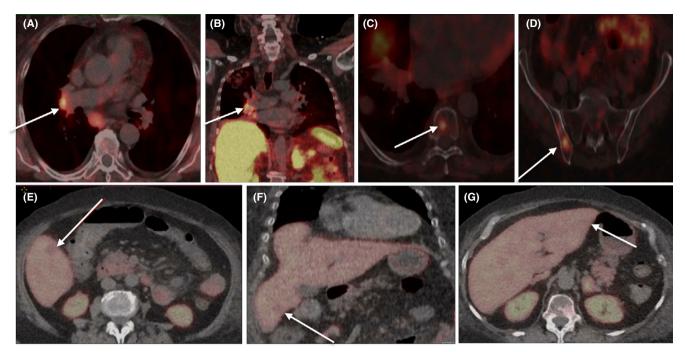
[⁶⁸Ga]-DOTATATE PET/CT demonstrated uptake in the right hilar area (A, B), 8th thoracic vertebra (C) and right iliac bone (D) but failed to identify three liver metastases, apparent on MRI, and confirmed by biopsy. Right liver lobe metastases (E, F) and left liver lobe metastasis (G) in a patient with NET of unclear primary origin. NET, neuroendocrine tumour [Colour figure can be viewed at wileyonlinelibrary.com]
